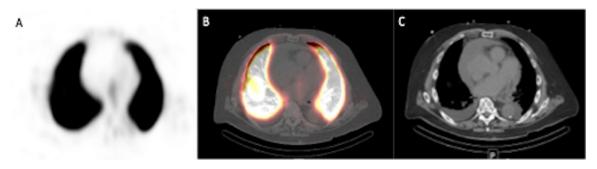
77-year-old man with laboratory diagnosis of COVID-19 with progressive dyspnea on evertion. Axial perfusion (Q)-only SPECT image (A) and fused Q-SPECT/CT (B) showing bilateral homogenous radiotracer uptake, without focal perfusion pulmonary defect. Axial low dose CT shows moderate sized pericardial effusion and small bilateral pleural effusions, suspicious for decompensated cardiac failure.
